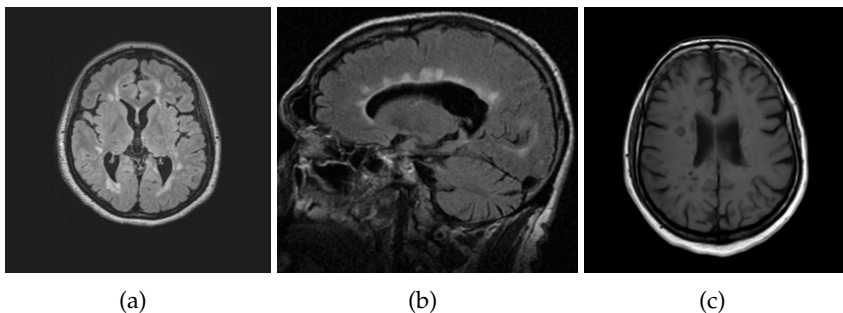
Some of the typical radiographic features of multiple sclerosis observed in three different patients on MR scans: (a) multi-focal areas of hyperintensity on FLAIR (image source: case courtesy of Henry Knipe, radiopaedia.org, rID: 30252), (b) hyperintense Dawson's fingers on FLAIR (image source: case courtesy of Frank Gaillard, radiopaedia.org, rID: 35916), (c) T1w "black hole" lesions (image source: case courtesy of Ahmed Abdrabou, radiopaedia.org, rID: 35195)
